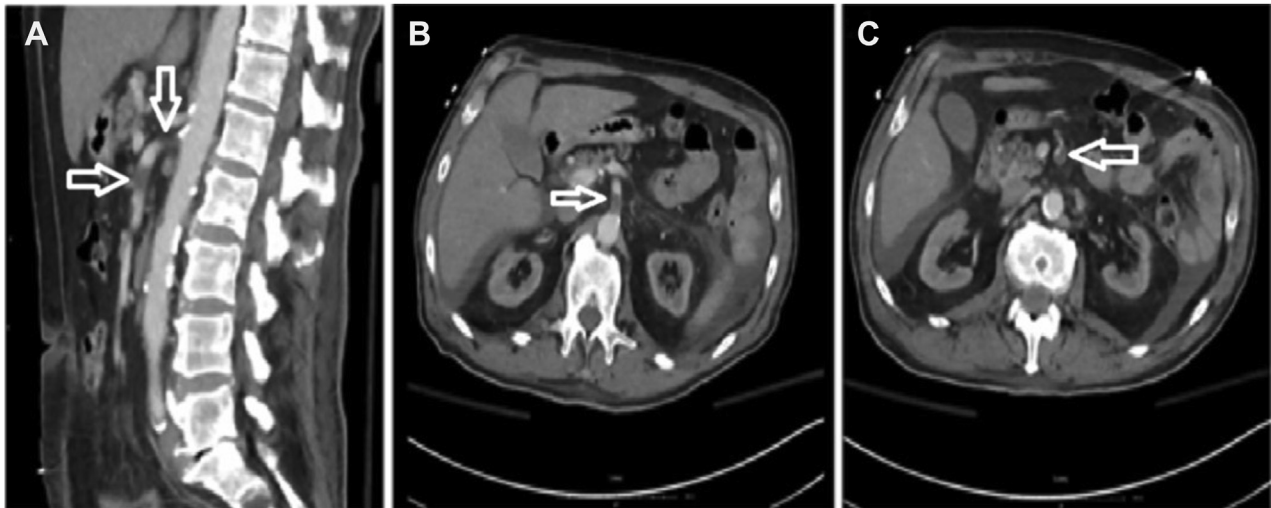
Contrast-enhanced CT of the abdomen and pelvis, sagittal (A) and axial (B, C) views, demonstrates a filling defect (arrows) from an embolus in the superior mesenteric artery.
